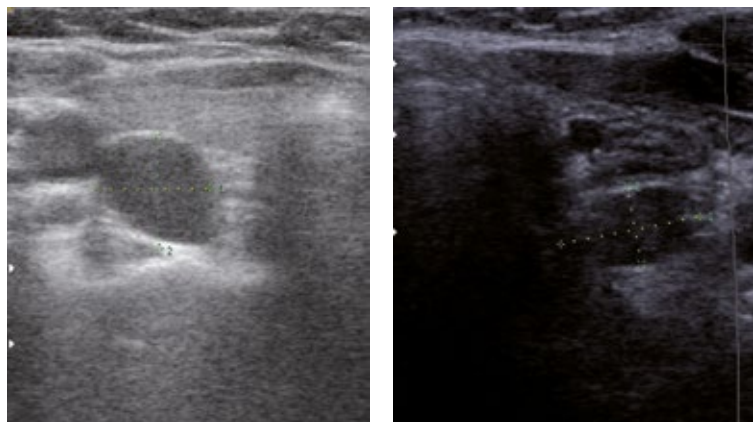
Parathyroid adenoma (a) and enlarged lymph node (b) – ultrasound image
